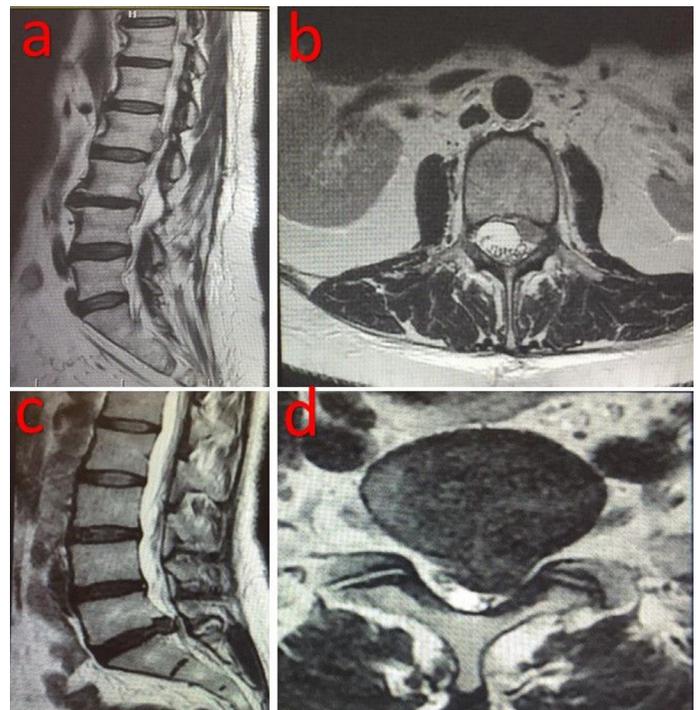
Non-contrast MRI of patient with lumbar disc herniation superiorly migrating left L2-3 (a): T2 sagittal MRI image revealing L 2-3 left lumbar disc herniation migrating upwards (b): Axial MRI image of the same patient (c): Non-contrast T2 sagittal MRI image revealing L5- S1 left paramedian lumbar disc herniation (d): Axial MRI image of the same patient
